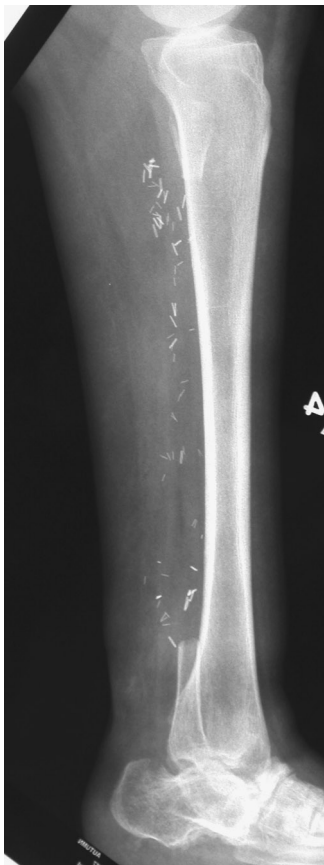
Preoperative lateral radiograph of the leg.
